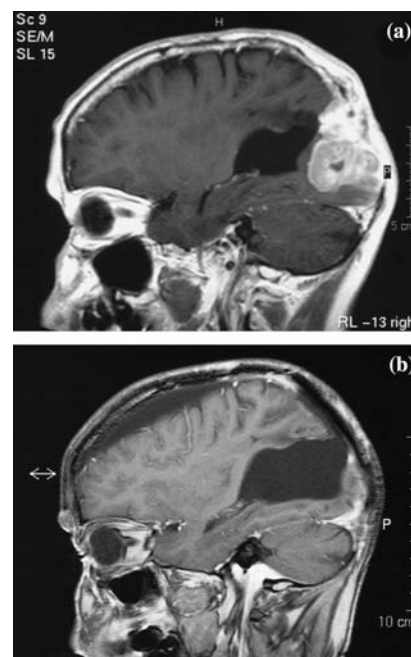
MRI obtained at diagnosis of a secondary tumour in the previously irradiated field (a). Complete remission 16 months later after subtotal resection of an undifferentiated sarcoma and seven cycles of epirubicin and ifosfamide (b).
